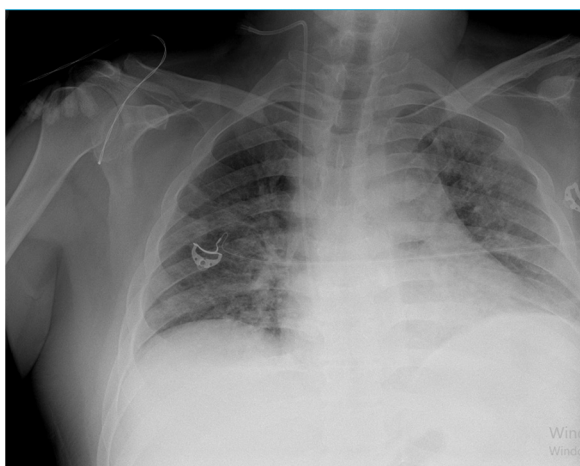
Chest radiography showing regression of radiological findings.
